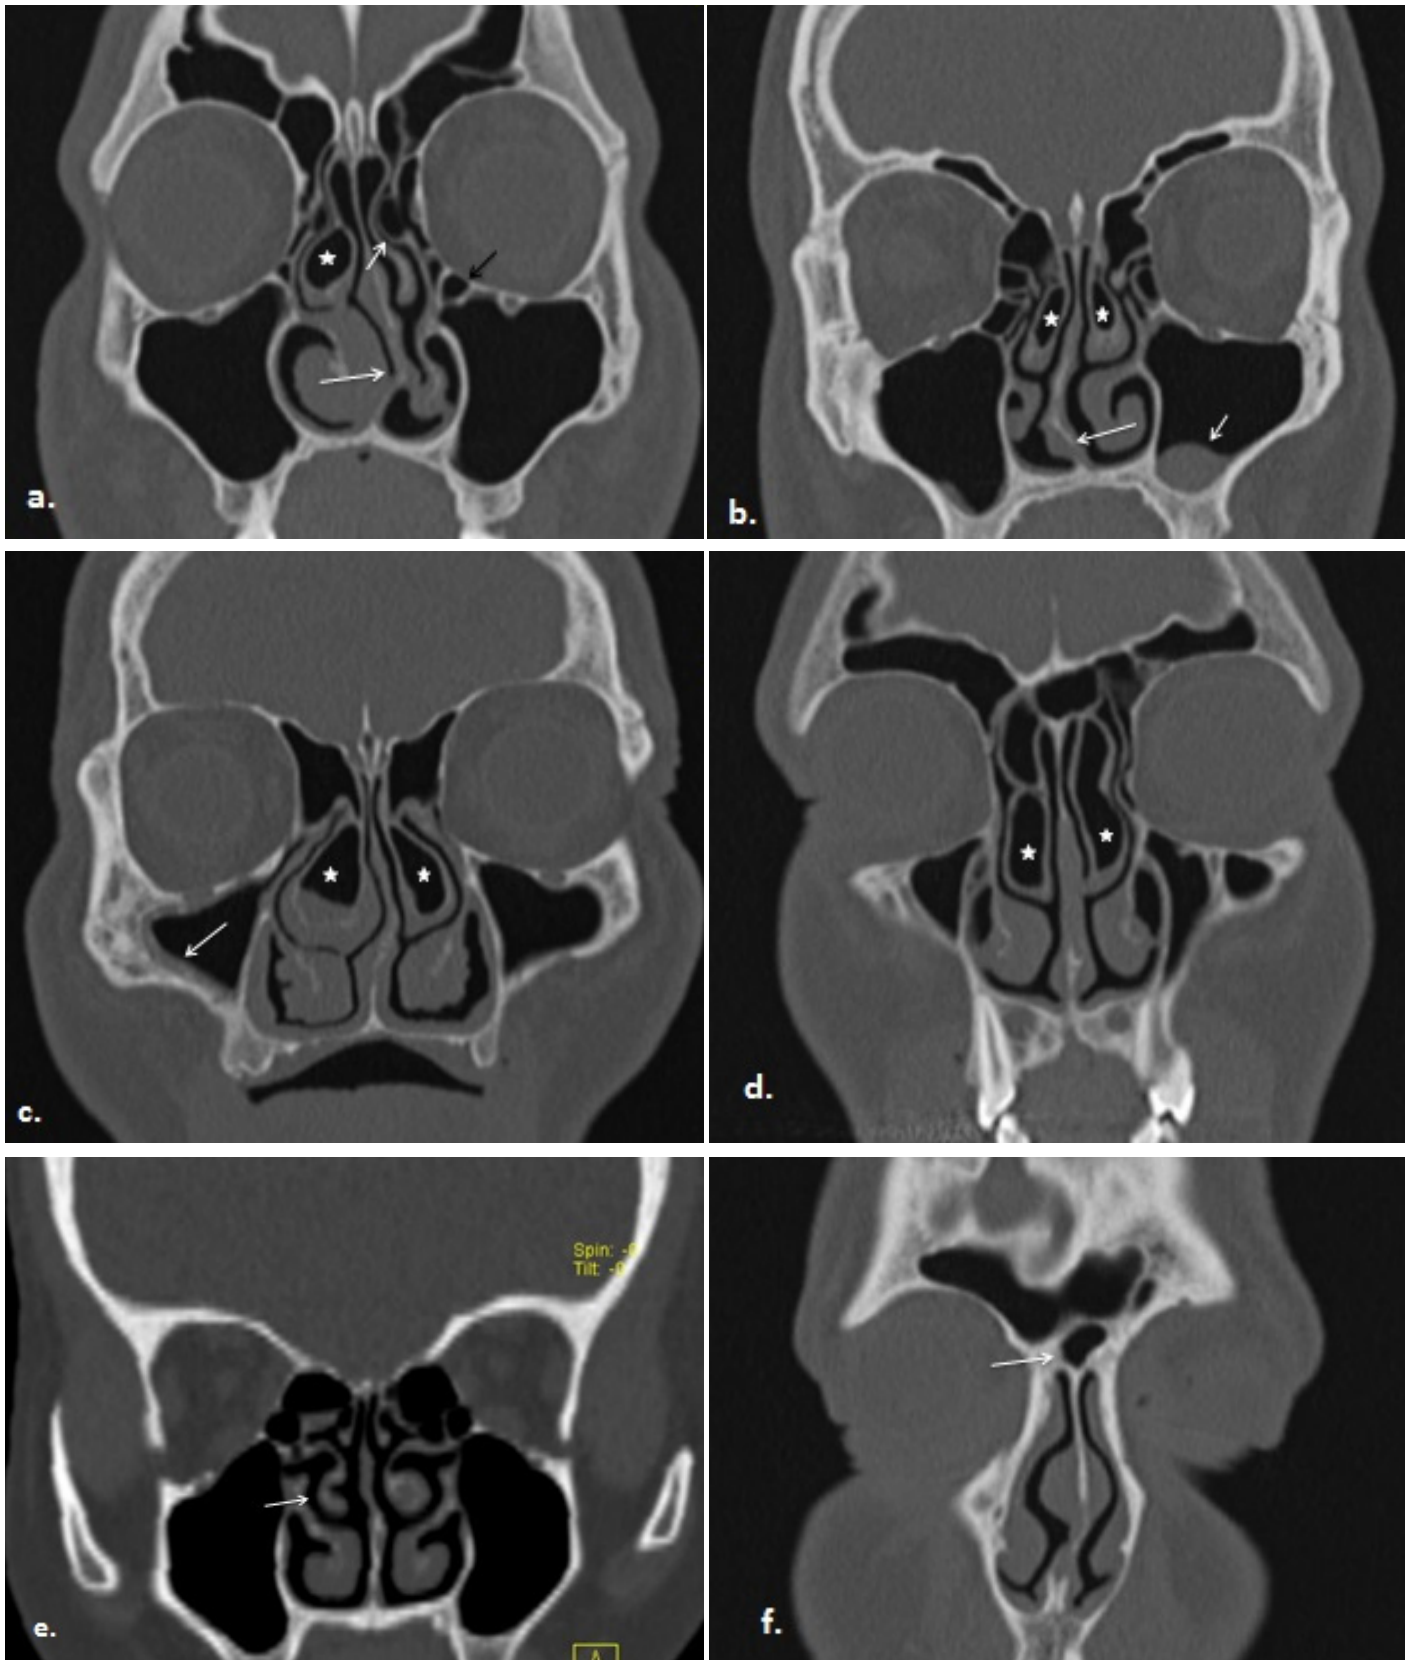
Coronal CT images (a-e) show different sinonasal anatomic variations. a: Left sided nasal septum deviation (long white arrow), right bulbous type concha bullosa (star), left uncinat cell (short white arrow) and left Haller cell (black arrow); b: Right-sided nasal septum deviation (long white arrow), mucosal thickening of the left maxillary sinus (short white arrow) and bilateral lamellar type concha bullosa (stars); c: Bilateral bulbous type (fluid within right side) concha bullosa (stars) and mucosal thickening of the right maxillary sinus (arrow); d: Bilateral extensive type concha bullosa (stars); e: Right paradoxical middle turbinate (arrow); f: Agger nasi cell (arrow).
